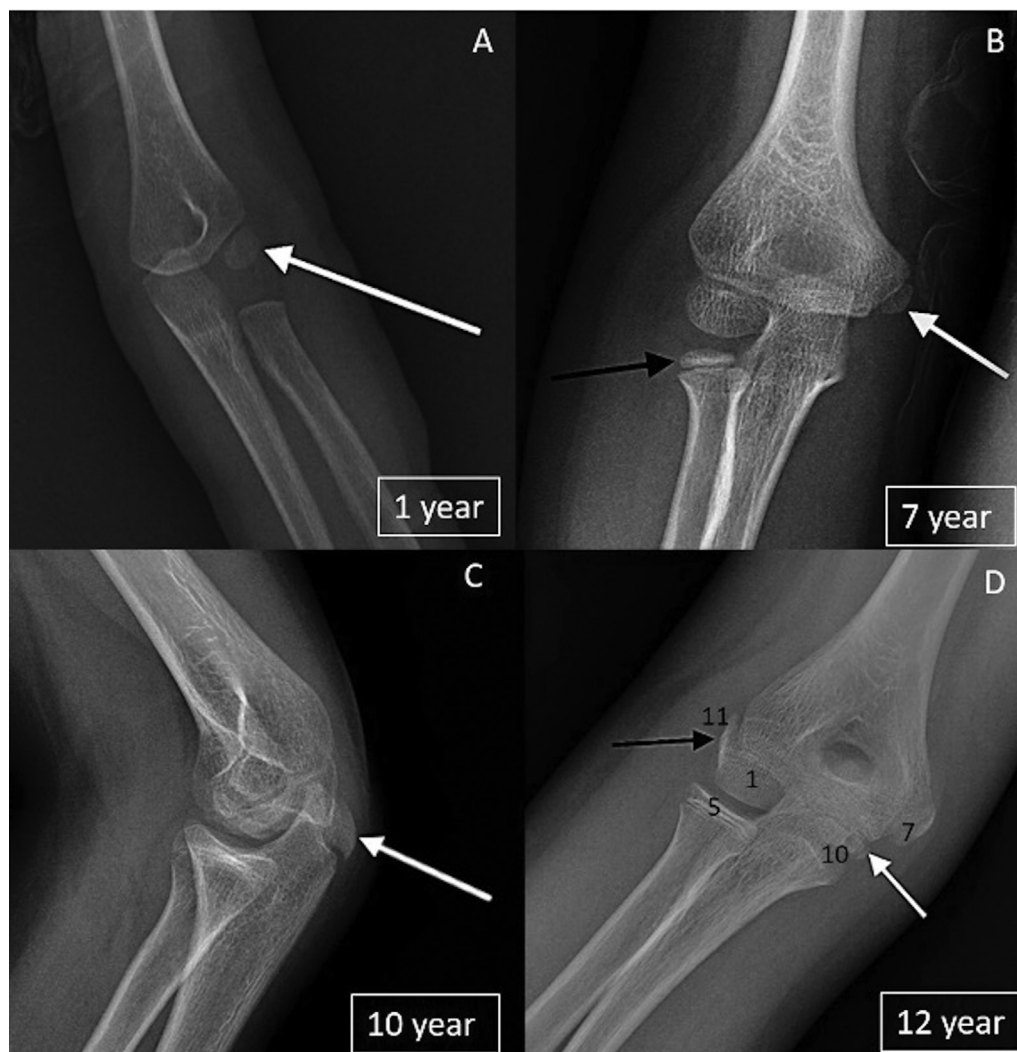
Radiographs of elbow joint of four male children showing (A) capitellum (white arrow), (B) radial head (black arrow) and medial epicondyle (white arrow) (C) olecranon (white arrow) in lateral view, (D) trochlea (white arrow) and lateral epicondyle (black arrow). Appearance of various structures around elbow joint representing age in years has also been depicted in the last image (age corresponding to the X-ray images are indicated in boxes).
